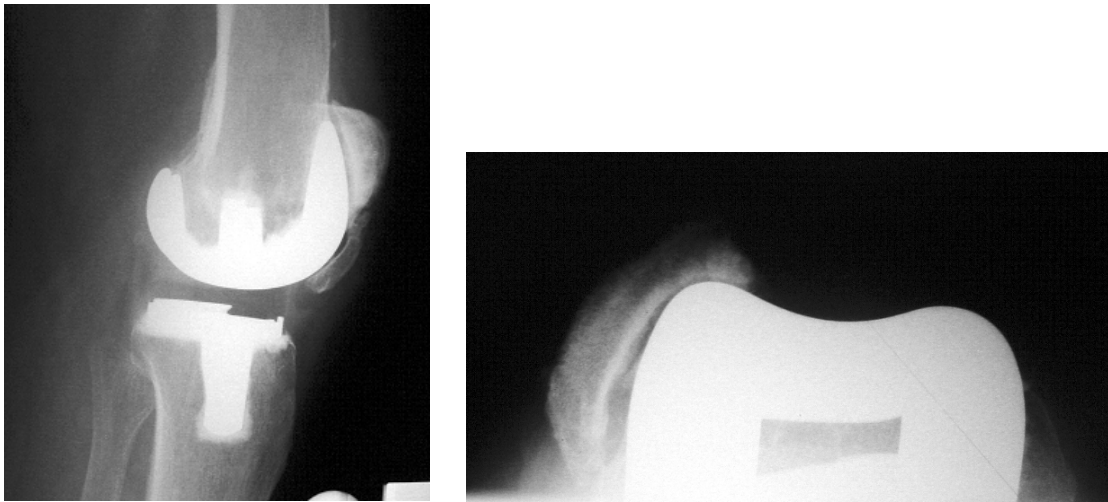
Lateral and skyline radiographs demonstrate patella subluxation as a result of component malrotation (¹⁰).
